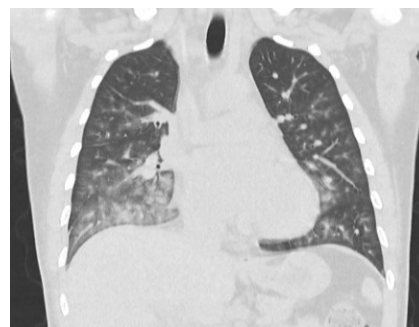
Multiple irregular ground-glass opacities were seen in the bilateral lungs on a computed tomography (CT) scan.
